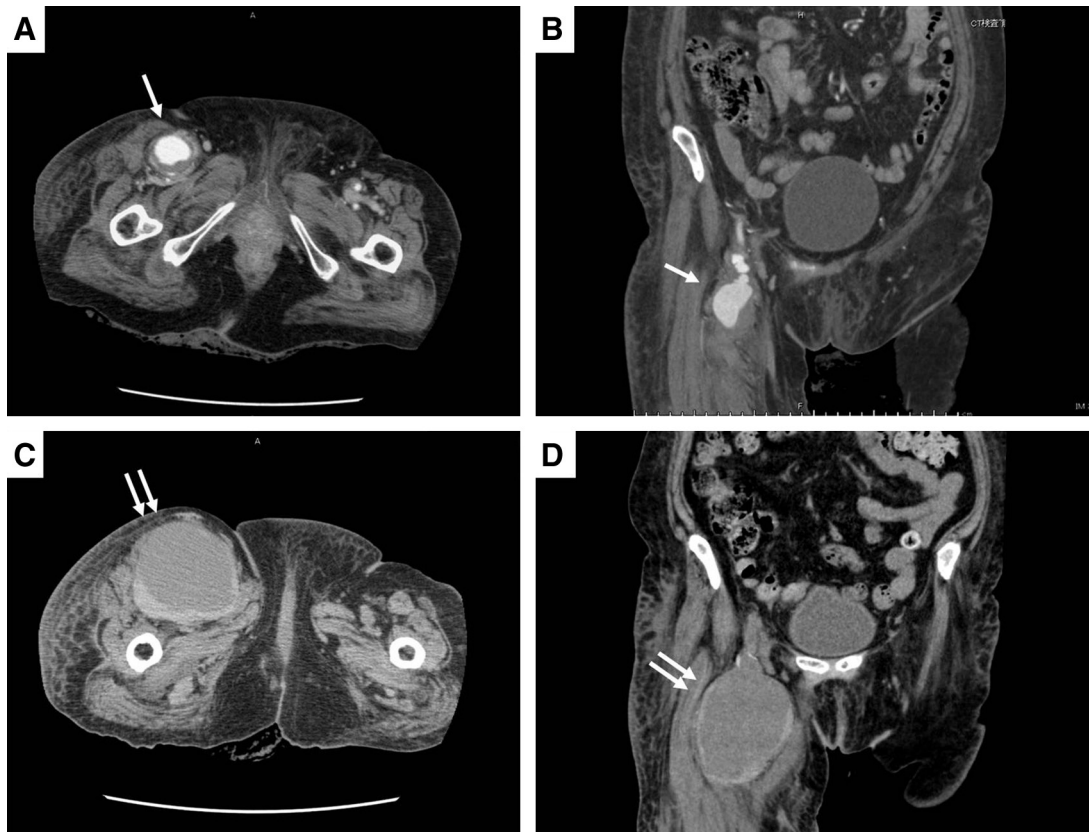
Horizontal view (A) and coronal view (B) on contrast-enhanced CT of the lower limb at 2 weeks after onset: Pseudoaneurysm with a maximum size of approximately 5 cm (arrow) was present at the arterial puncture site of the right thigh. Horizontal view (C) and coronal view (D) on plain CT of the lower limb at 5 weeks after onset: The pseudoaneurysm enlarged and its maximum diameter increased to approximately 11 cm (double arrow).
